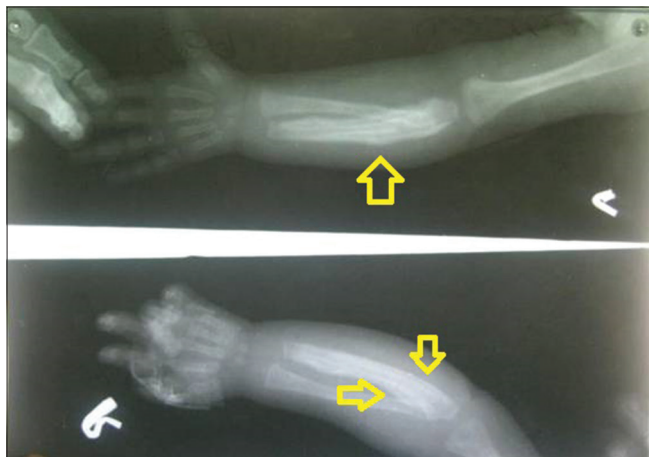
X-ray of forearm bones showing subperiosteal reaction of right and left ulna
